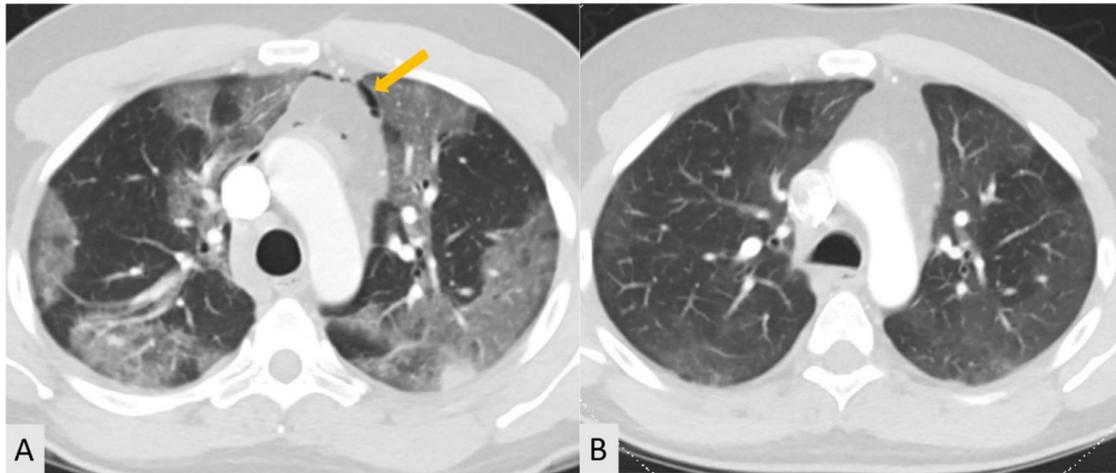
(A) Initial axial chest CT with moderate amount of ground-glass opacity with a peripheral lung distribution (note there is also pneumomediastinum (arrow)) and (B) Axial chest CT 1 month later with much less dense residual ground-glass opacification in a similar distribution.
